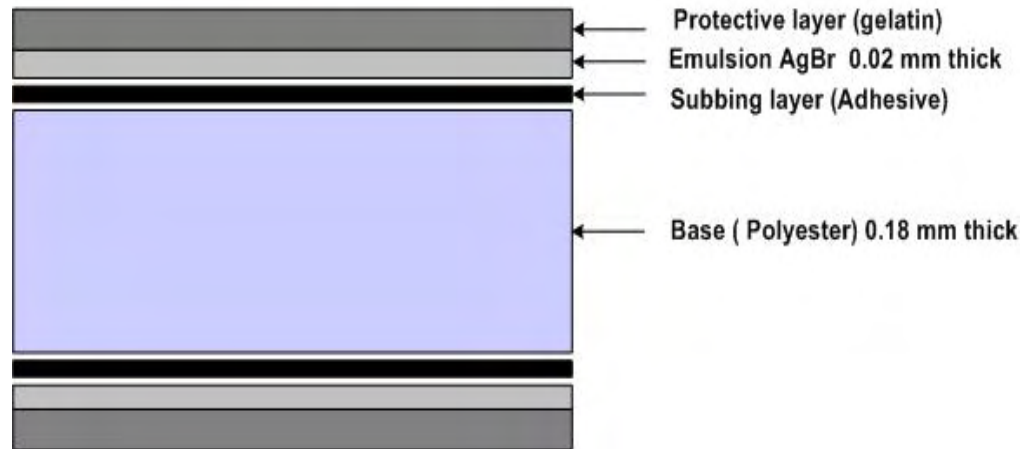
A cross-sectional view of radiographic film layers.
